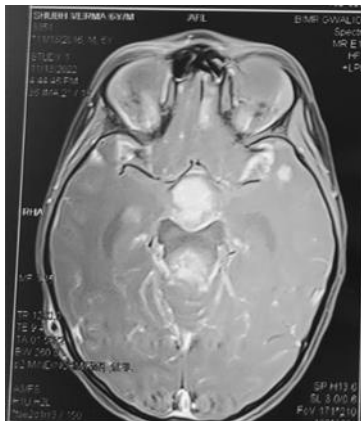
Post-op MRI-brain s/o. In a post-operative case of medulloblastoma present study shows residual/recurrent lesion in the 4th ventricle with associated leptomeningeal, parenchymal and suprasellar cistern metastases.
